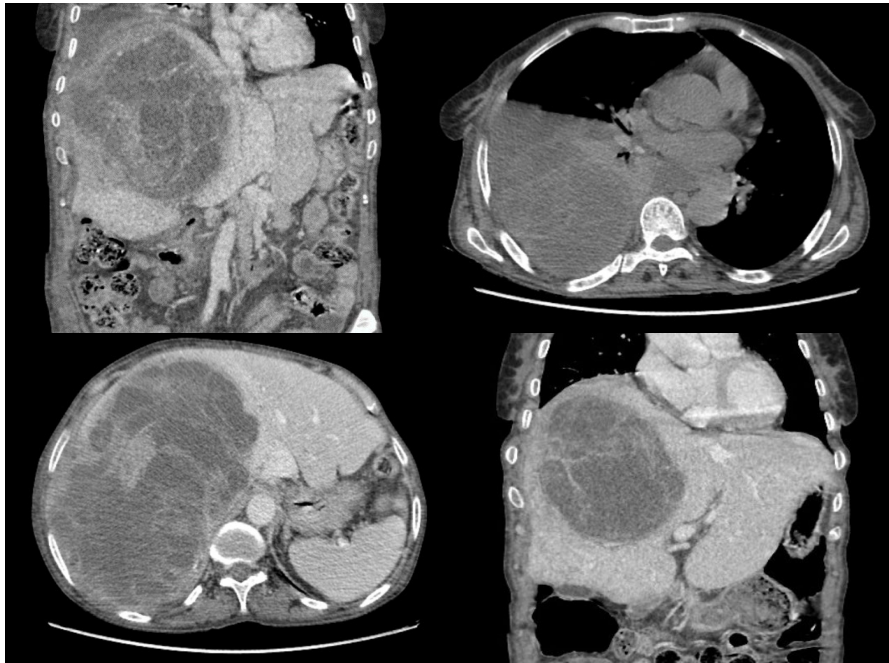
Dynamic CT images of the mass
